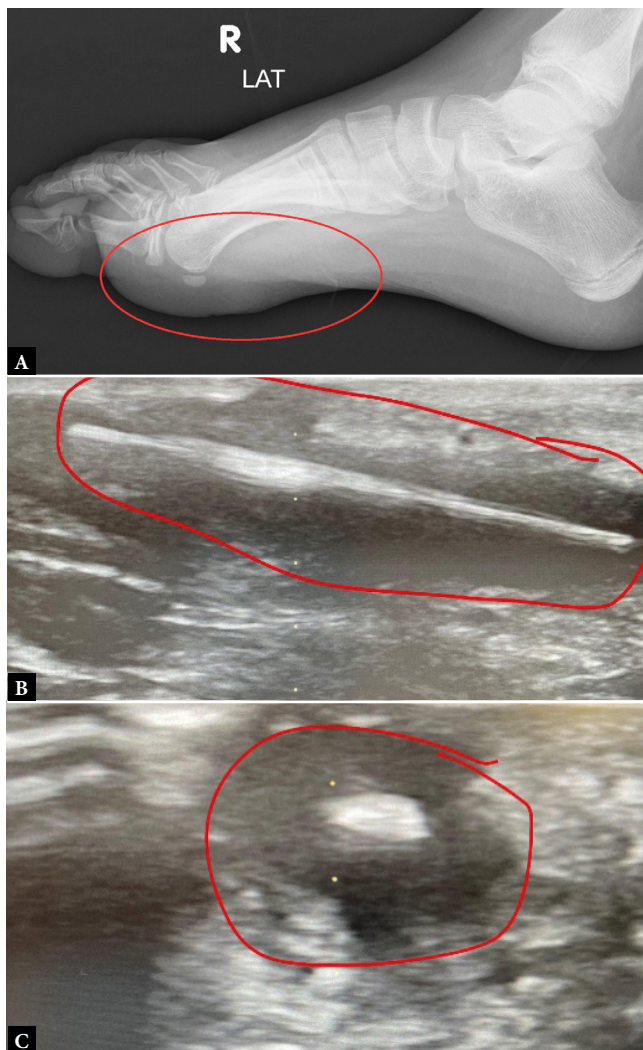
A. X-ray of the right foot, lateral view, no visible foreign body. B, C. US of the right foot, thin linear foreign body visible
